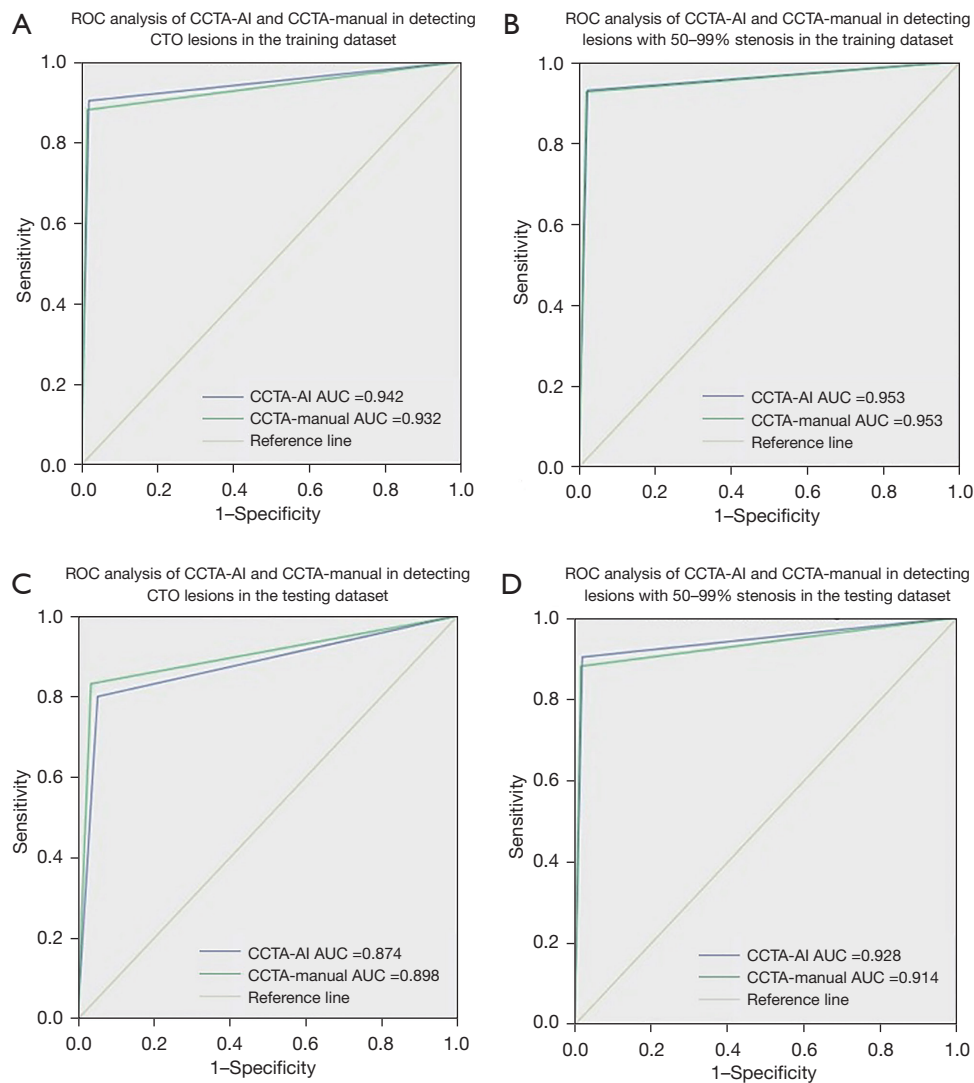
ROC analysis of CCTA-AI and CCTA-manual in detecting CTO lesions and lesions with 50–99% stenosis. (A) ROC analysis of CCTA-AI and CCTA-manual in detecting CTO lesions in the training dataset; (B) ROC analysis of CCTA-AI and CCTA-manual in detecting lesions with 50–99% stenosis in the training dataset; (C) ROC analysis of CCTA-AI and CCTA-manual in detecting CTO lesions in the testing dataset; (D) ROC analysis of CCTA-AI and CCTA-manual in detecting lesions with 50–99% stenosis in the testing dataset. ROC, receiver operating characteristic; CCTA, coronary computed tomography angiography; AI, artificial intelligence; CTO, chronic total occlusion; AUC, area under the curve.
